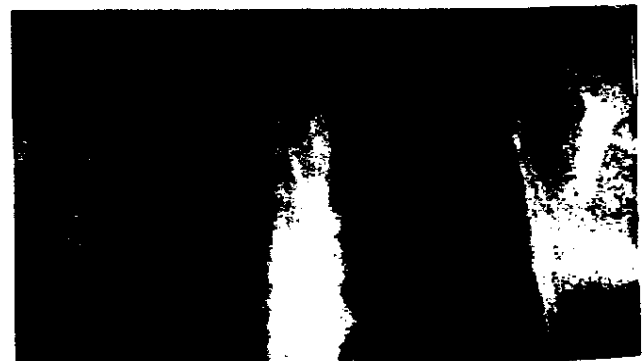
Chest radiograph revealing asymmetry of the SCJs.
